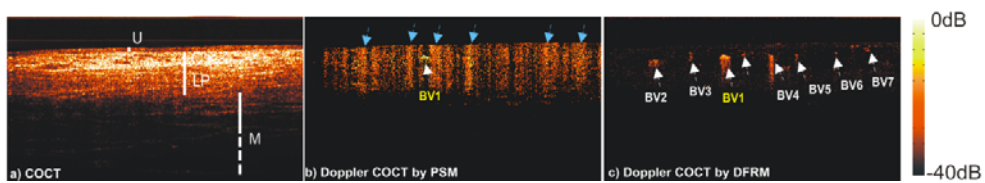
Endoscopic FDOCT images of human bladder *in vivo*. a): structural OCT image, b), c) Doppler OCT images reconstructed by PSM and DFRM (single frequency thresholding at 0.2π), respectively. U: urothelium, LP: lamina propria, M: muscularis. White arrows: blood vessels (BVs); blue arrows: vertical stripes (phase noises) induced by bladder motion or surgeon's handshaking.
